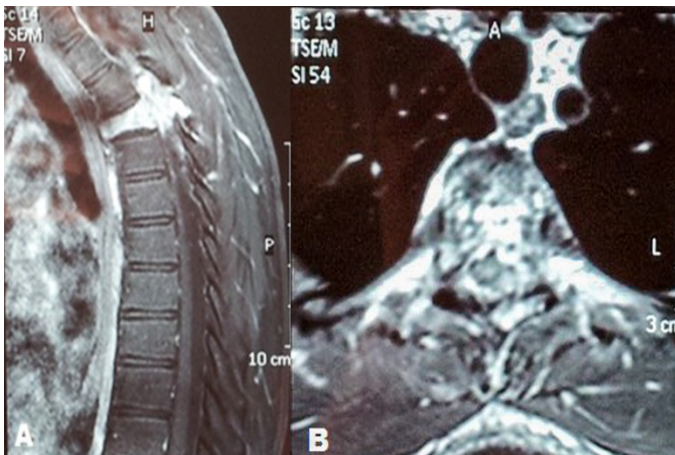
(a) T2-weighted MRI of the sagittal spine – presence of hypersignal suggesting compressive myelopathy, severe kyphotic deformity. (b) T2-weighted axial spine MRI – large, expansive lesion with multiple fluid levels and secondary spinal cord compression
